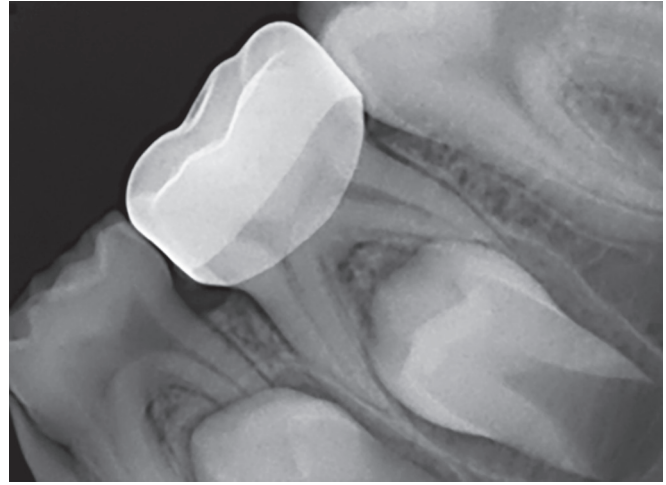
Six months postoperative digital intraoral periapical image
